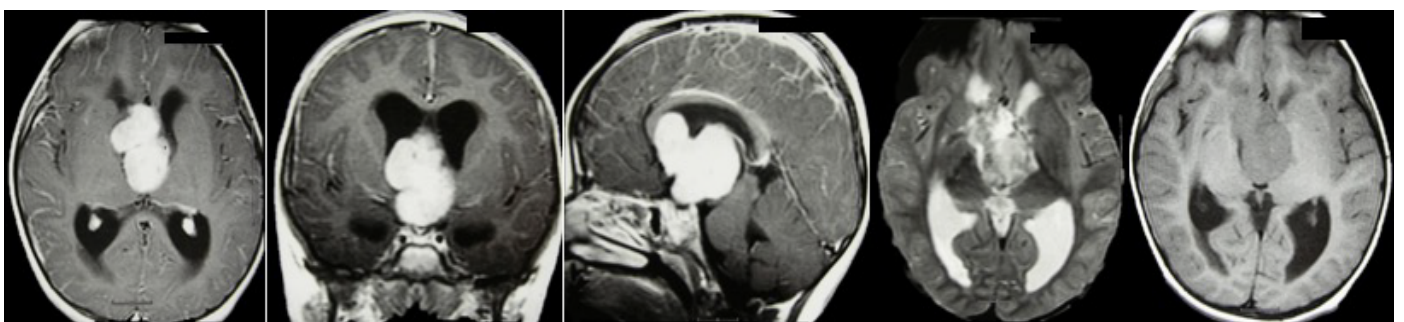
MRI study of Case 2; preoperative axial, coronal and sagittal T1W images showing a lobulated huge mass homogenous enhancement after gadolinium injection with compression of venous structures as well as ventricular dilatation. Axial T2W image shows a heterogeneous hypointense mass while axial flair images reveal isointensity of the mass with no periventricular passage of CSF.
